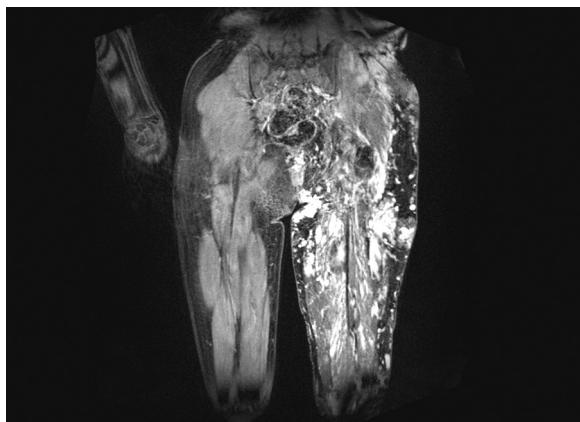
MRI scan with contrast
